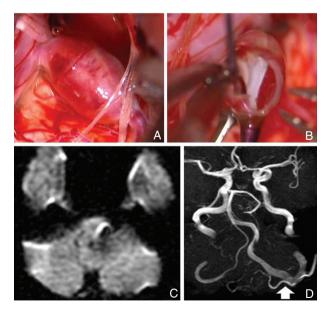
A: The aneurysmal wall was red and thin. B: The aneurysm had thrombus present. C: Postoperative magnetic resonance image shows no infarct lesion. D: Magnetic resonance angiography shows flow of the occipital artery-posterior inferior cerebellar artery anastomosis.
